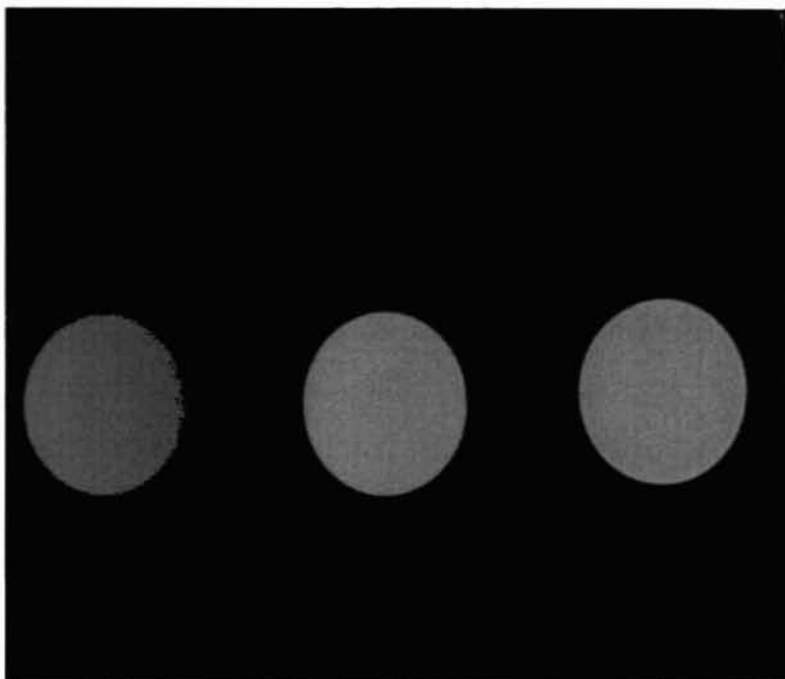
X-ray photograph of NR-ZnO/E systems at amount varying from 50 - 150 phr
